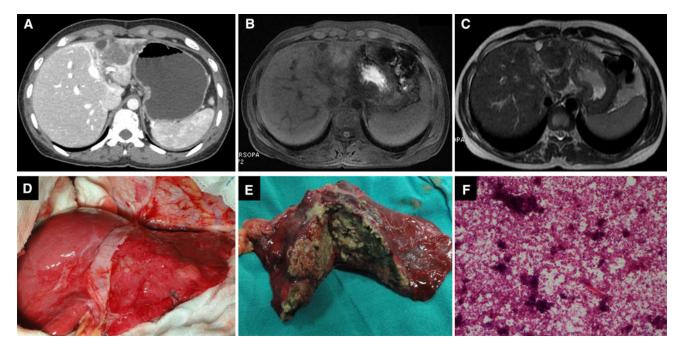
Contrast-enhanced CT (portal venous phase) of 30-year-old female patient (A) shows small left lobe with nodular hypodense lesions. Corresponding MR scan displaying varying signal intensities on B T1- and C T2-weighted images. Intraoperative photograph (D) showing lesion in the left
